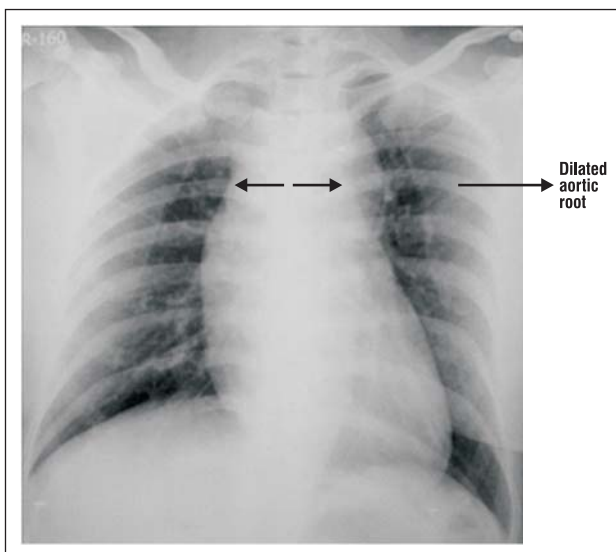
Chest X-ray showing widened superior mediastinum.
